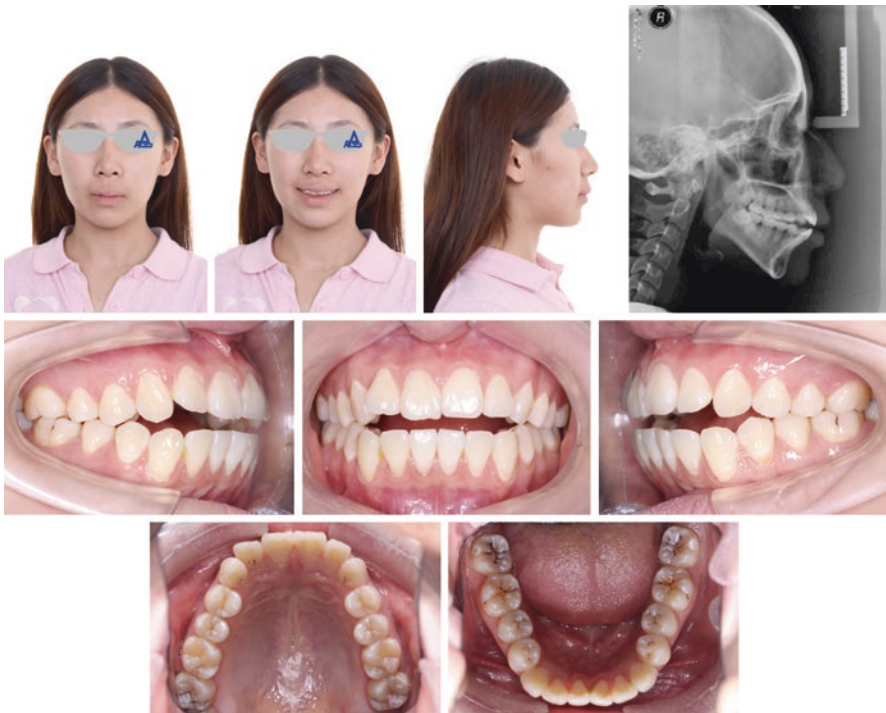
Pretreatment facial and intraoral photographs, as well as radiograph
